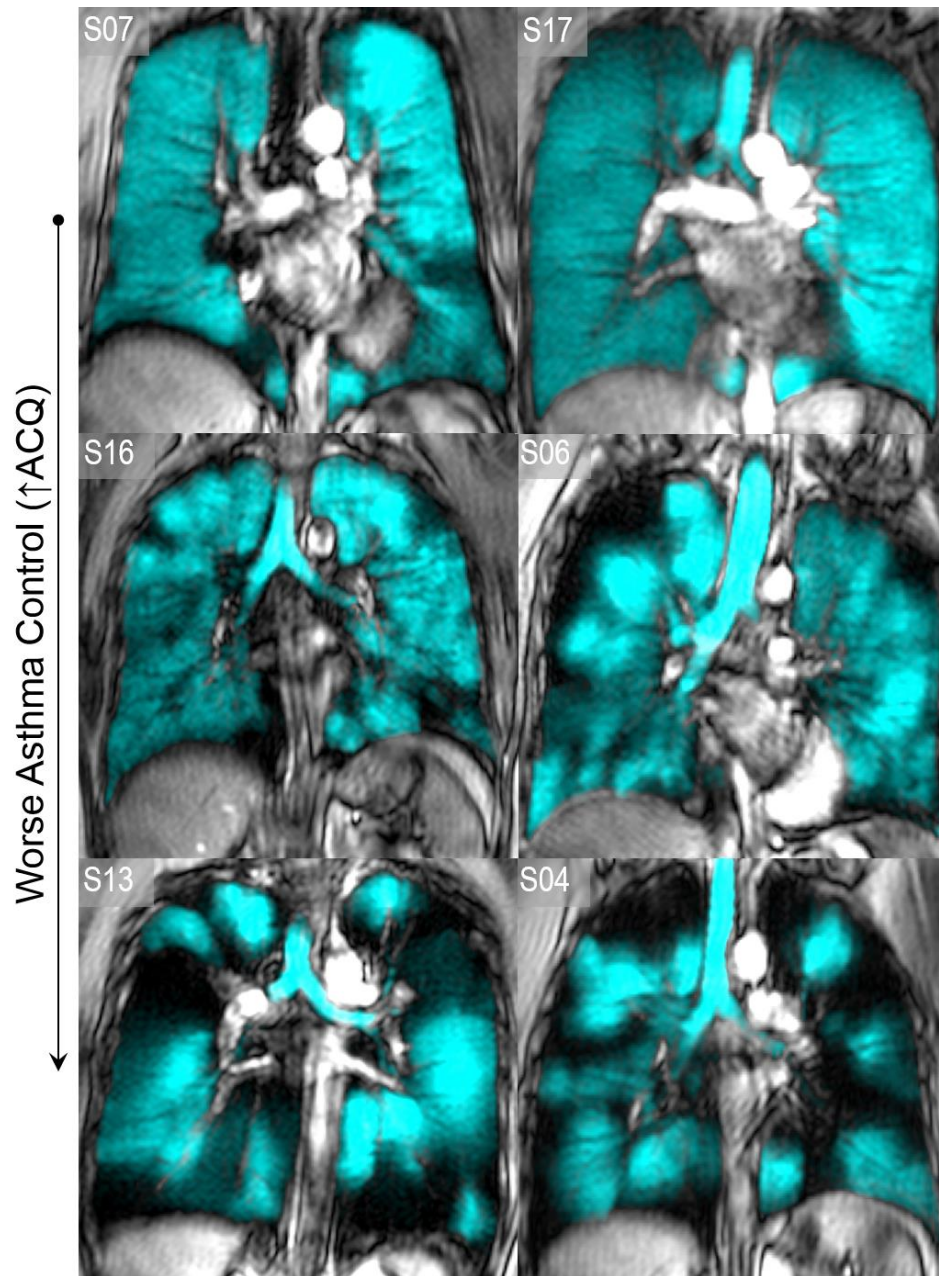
Hyperpolarized ³He MRI of representative patients with severe asthma. Centre coronal slice ³He MRI ventilation in blue co-registered to anatomical ¹H MRI in grey-scale for six representative severe asthmatics. S07: 55 year-old female, FEV₁=77%_{pred}, ACQ=1.4, LCI=9.7, VDP=2%; S17: 39 year-old female, FEV₁=66%_{pred}, ACQ=1.7, LCI=6.7, VDP=3%; S16: 48 year-old male, FEV₁=78%_{pred}, ACQ=2.3, LCI=8.6, VDP=8%; S06: 45 year-old male, FEV₁=34%_{pred}, ACQ=2.7, LCI=11.5, VDP=14%; S13: 56 year-old male, FEV₁=34%_{pred}, ACQ=3.1, LCI=17.5, VDP=33%; S04: 60 year-old female, FEV₁=47%_{pred}, ACQ=4.3, LCI=14.0, VDP=35%.
